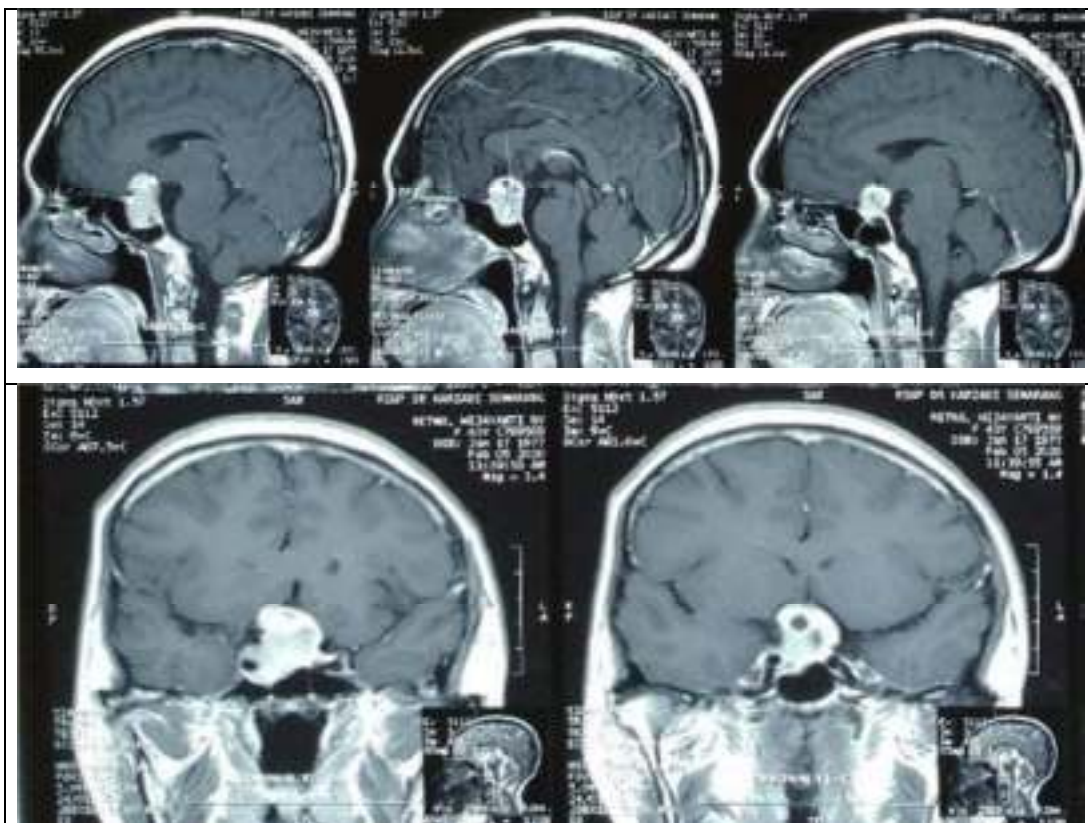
Brain MRI on the first admission. Preoperative MRI revealed a pituitary adenoma, which extends to the right parasella (AP 2.71 cm x CC 2.81 cm x LL 2.72 cm) causing an encasement of the right internal carotid artery as well as compression in the intracranial part of the right optic nerve and optic chiasm. There was no bleeding or sign of elevated intracranial pressure.
